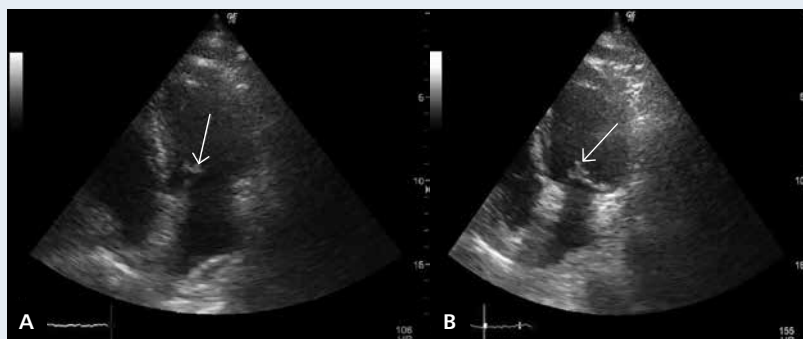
A, B. Transthoracic echocardiography; vegetation associated with mitral valve (arrow)
